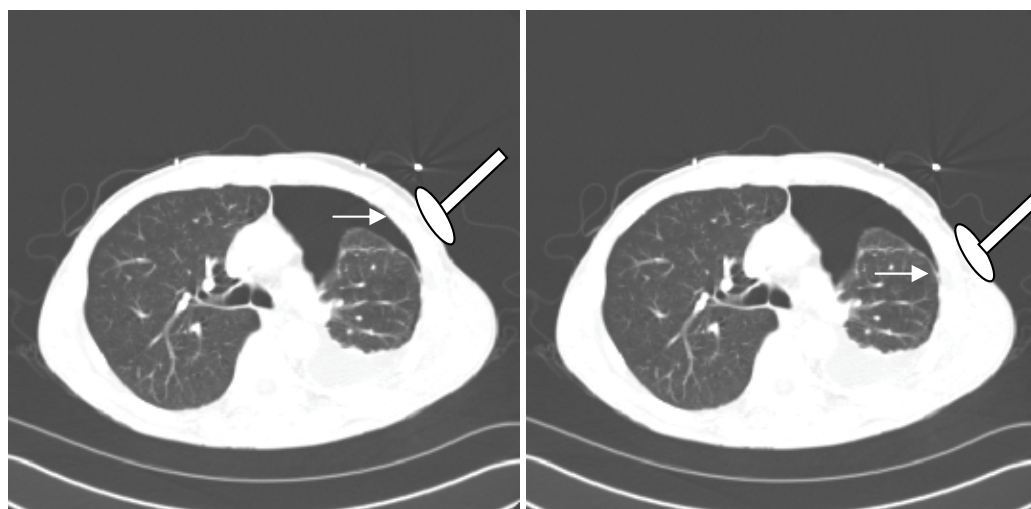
Lung point sign. With the probe at this point, during expiration (1), the lung contracts, air comes between the pleural space (arrow). During inspiration (2), lung expands and slides in the ultrasound plane (arrow)
